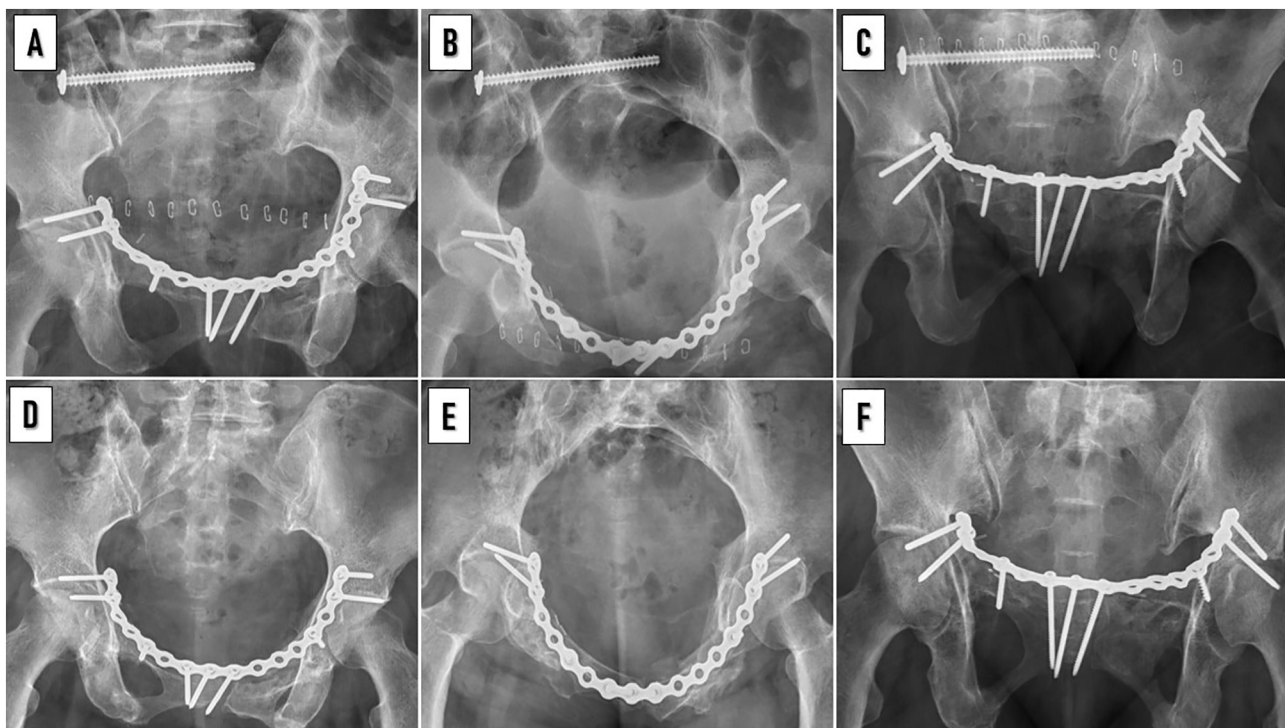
Post-operative radiographs after initial pelvic ring fixation. Antero-posterior view (A), Inlet view (B), Outlet view (C). Post-operative radiographs after sacroiliac screw removal. Antero-posterior view (D), Inlet view (E), Outlet view (F).
